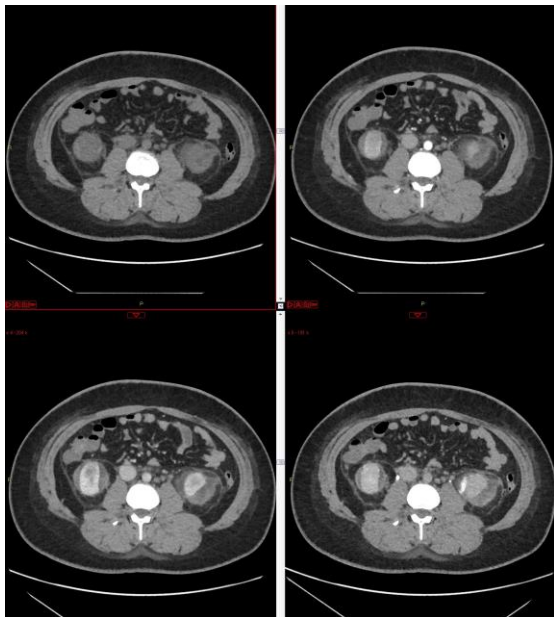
CT before and after contrast agent administration, on axial planes. On late excretory phase (lower figure on the right) an extended contrast agent blush may be noted into the left perirenal hematoma, diagnosed as active bleeding.
